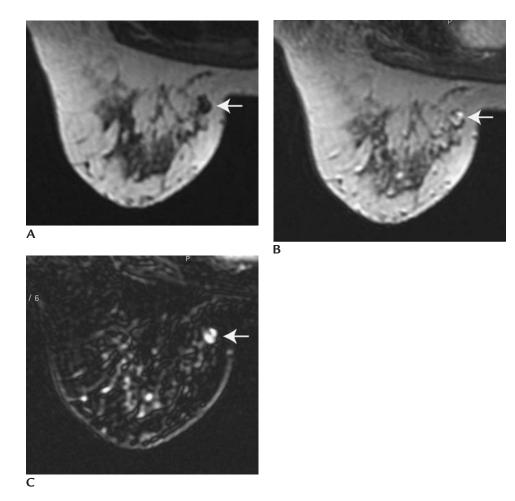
MRI, peripheral papilloma. (A) Axial pre-contrast T1-weighted image, right breast. Round mass (*arrow*) in the medial aspect of the right breast posteriorly, low signal intensity. (B) Axial, post-contrast T1-weighted image. Mass, with heterogeneous enhancement (*arrow*); rim does not enhance. (C) Subtraction image, enhancing mass (*arrow*).
